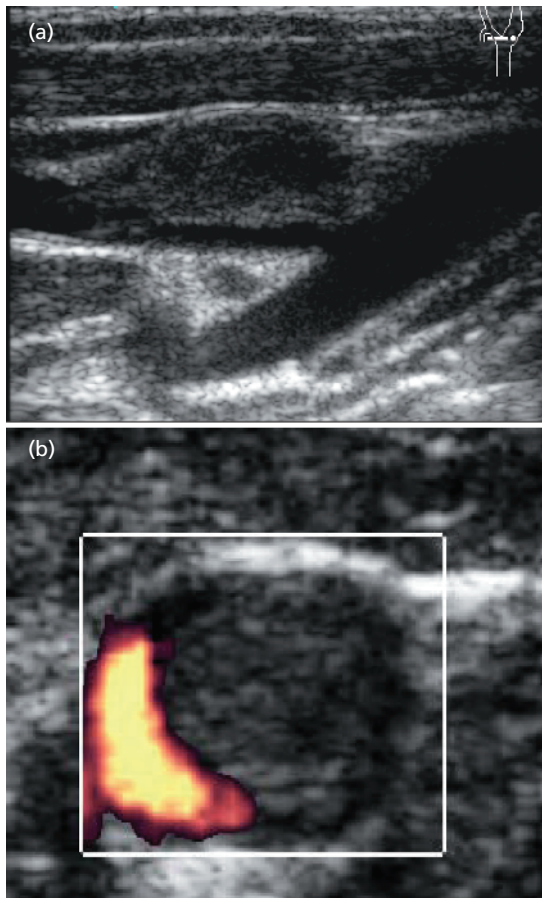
Carotid duplex visualization of a thrombus in the proximal ICA without underlying atheromatous stenosis. (a) Longitudinal brightness-modulated (B-mode) view of a large thrombus that is attached to the near wall occupying most of the carotid bulb. (b) Transverse view of the same thrombus with crescent moon-like appearance of the residual lumen on power Doppler.
